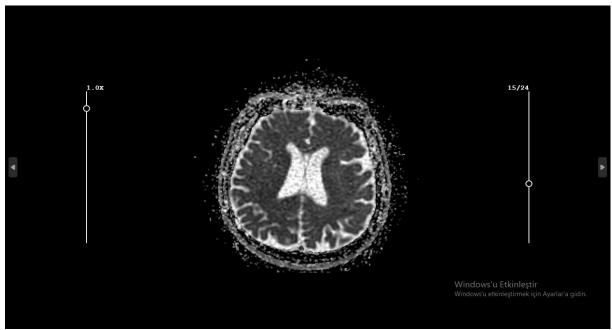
Diffusion-weighted examination of cranial magnetic resonance imaging (DWI). Cerebral sulcus depth and the ventricular system's width increased secondary toage-related parenchymal atrophic change.
